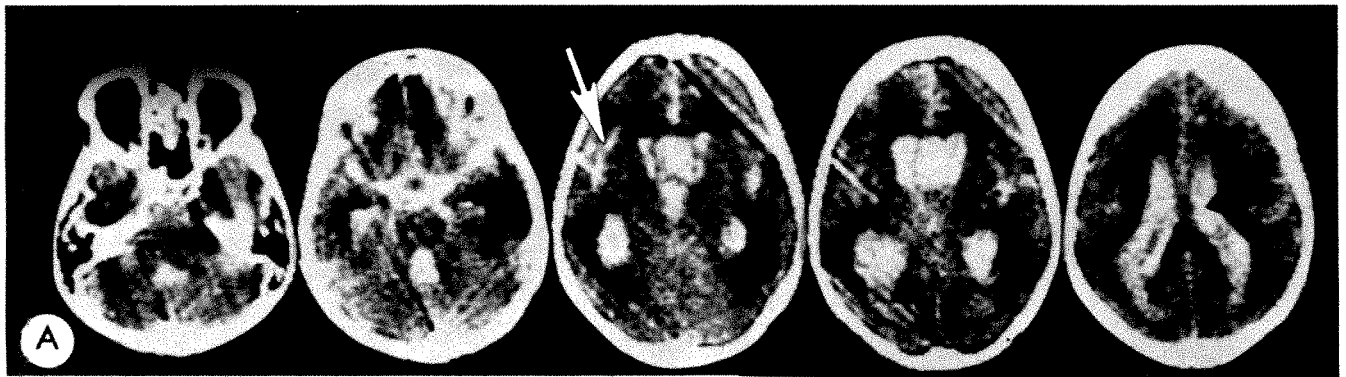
Criteria for poor prognosis. *A*, CT scan showing marked subarachnoid (arrow) and intraventricular (arrowhead) hemorrhage and blood in distended cavum of septum pellucidum. *B*, Left carotid angiogram, AP view, on same day showing aneurysm of communicating artery (arrow).
